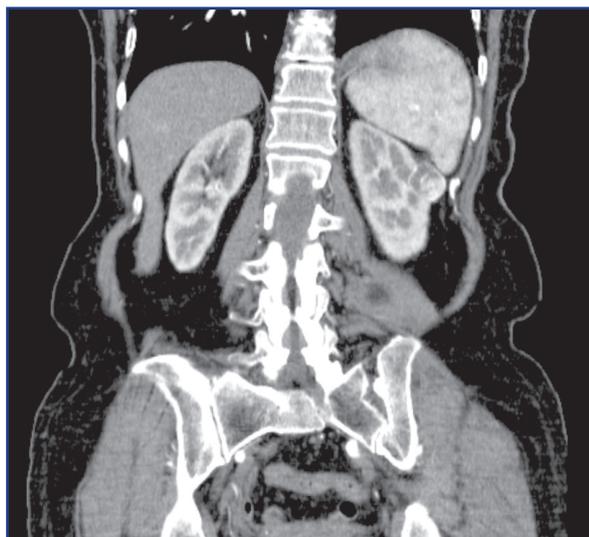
Abdominal CT scan of a left kidney tumor.
